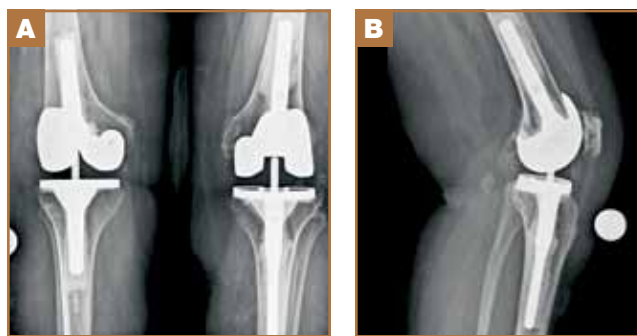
(A) Postoperative AP radiograph of bilateral total knees. (B) Postoperative lateral radiograph of left total knee arthroplasty.
